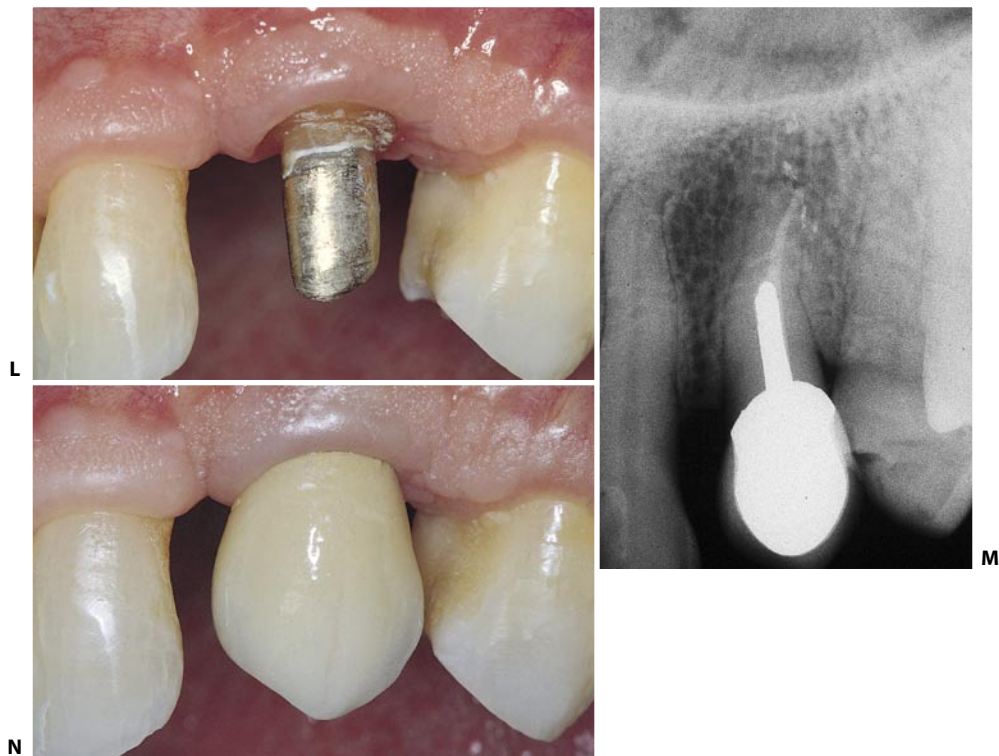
(continued) L. Reconstruction of the abutment with a cast gold post and core during the phase of tissue maturation. M. Final radiograph at completion of restoration. N. The completed prosthetic restoration.
